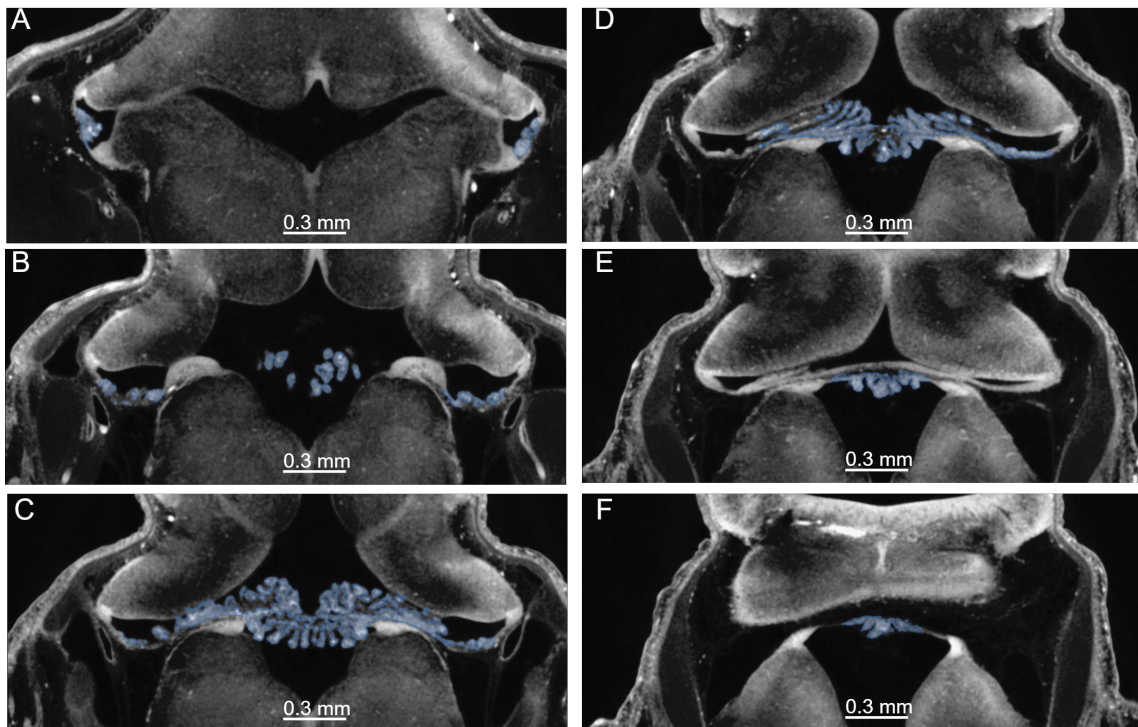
Appearance of the choroid plexus on frontal CT scans at comparable levels. The segmented region of the choroid plexus is within the blue contour. Dorsal shift through a-f.
